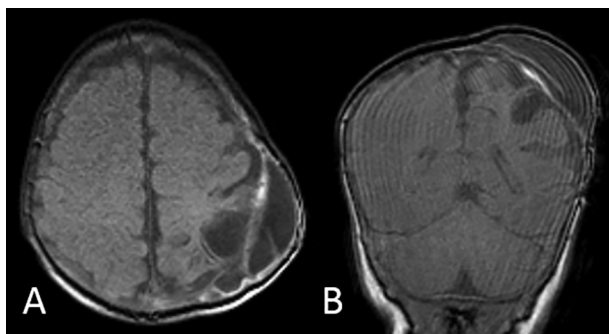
Axial (A) and coronal (B) T1-weighted MR images depict the persistence of a pseudomeningocele at 1 month after surgery. Movement artefacts partially affected the images quality.
